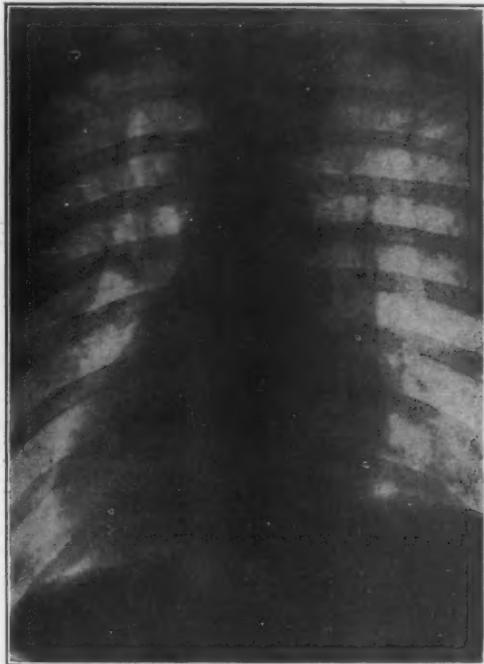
Radiograph by Dr. L. G. Cole, of tacks voluntarily aspirated by the patient.
